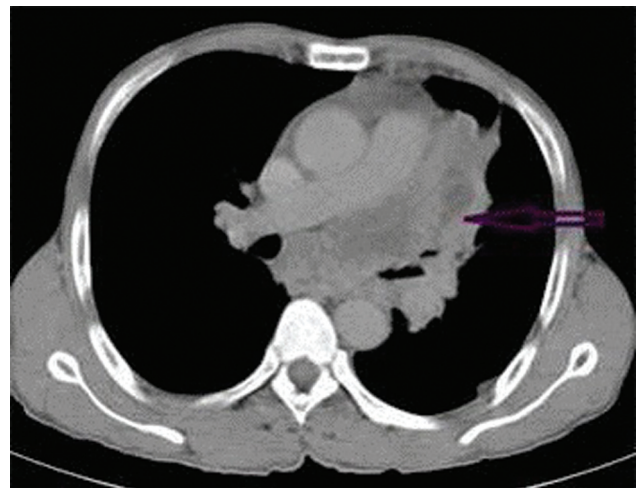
Axial contrast-enhanced computed tomography image demonstrating a left hilar mass (arrow) with moderate heterogeneous enhancement suggesting a diagnosis of carcinoma lung with mediastinal lymphadenopathy.
